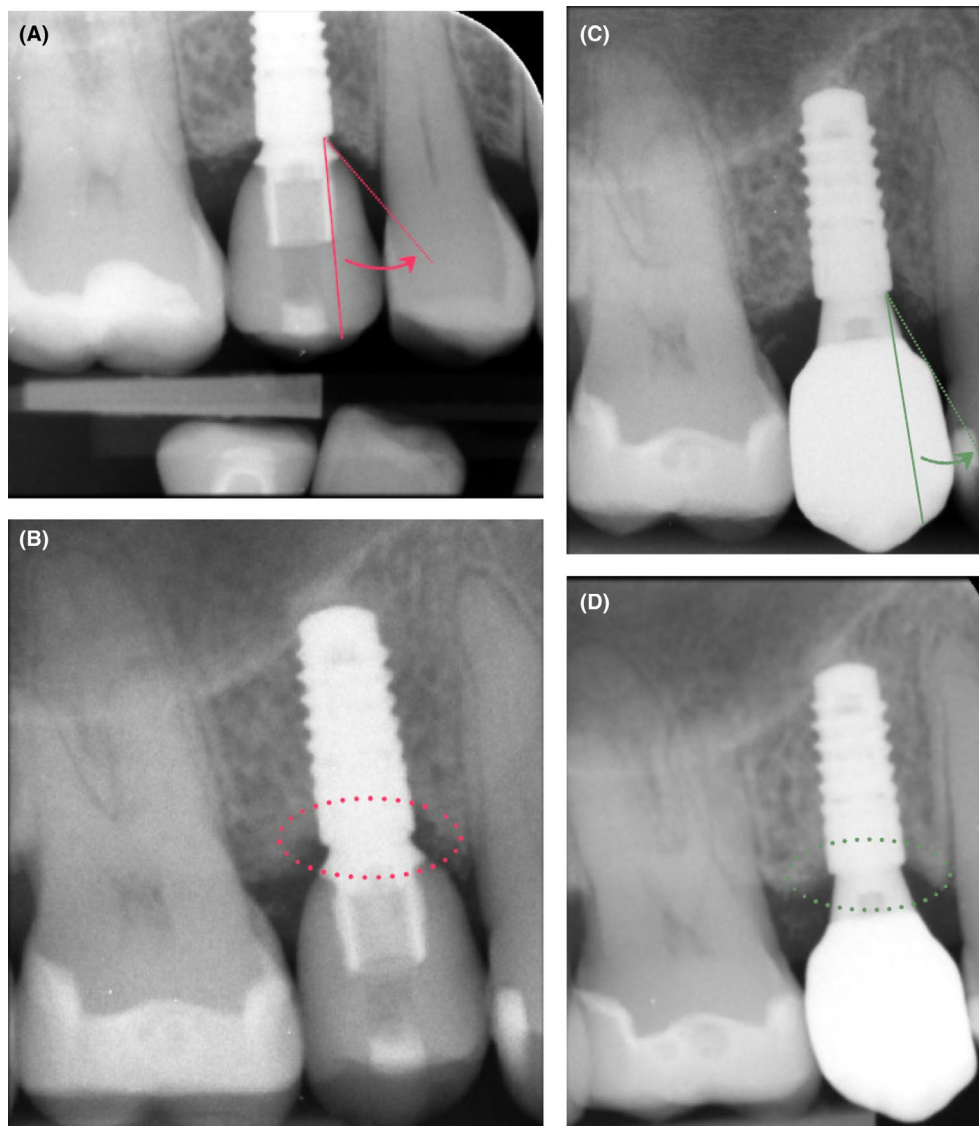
(A) This is a case of an implant in a maxillary second premolar site with a wide restorative emergence angle (EA) at crown delivery. The red dotted lines indicate the width of the angle. (B) After 4 years, the marginal bone loss can be observed (area within the red dotted line). (C) The crown was subsequently remade with a longer abutment, which effectively reduced the width of the restorative angle (green dotted lines). (D) A follow-up radiograph after 12 months shows remineralization and a radiographic gain in crestal bone height (area within the green dotted line).
